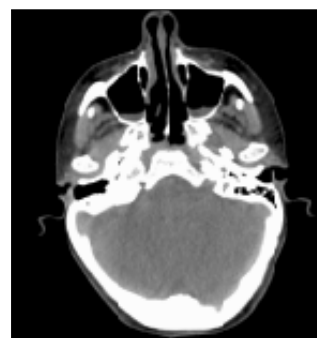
CT scan axial plane showing disappearance of external ear cartilages.
